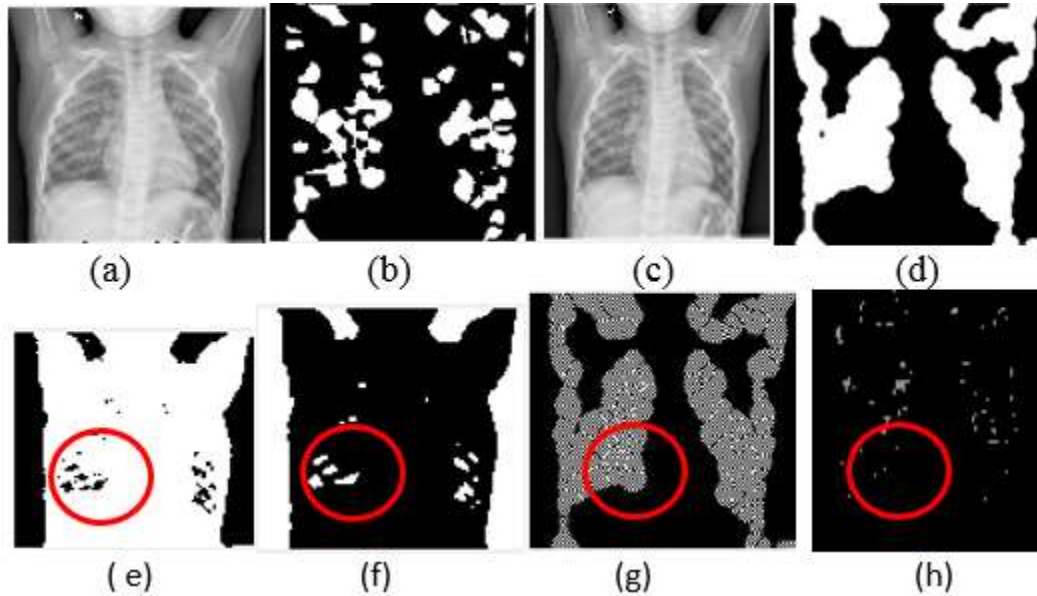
(a) - (h) Infected person COVID-19 within 3 days- Chest X-Ray Imaging - image feature extracted through fever.
